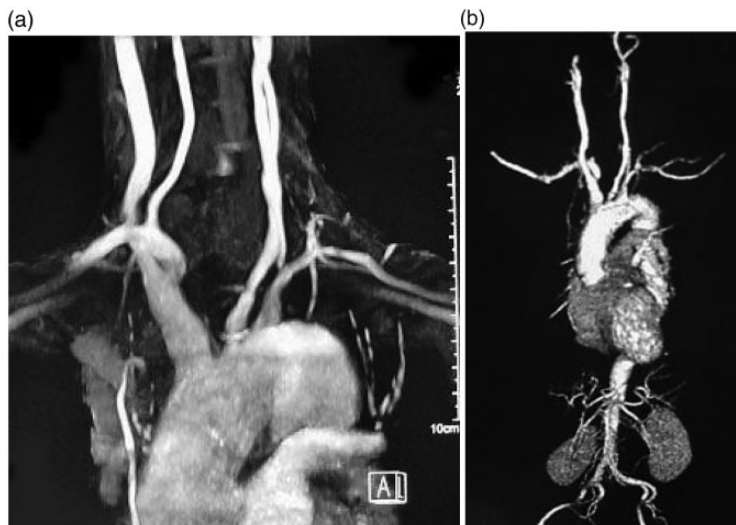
Imaging findings. (a) Chest magnetic resonance angiogram. Stenosis of the left subclavian artery and left-side common carotid artery is observed. (b) Contrast-enhanced three-dimensional computed tomography angiogram extending from the chest to the pelvis. Stenosis of the left subclavian artery and left-side common carotid artery is observed; however, there are no abnormalities in the main peripheral vessels branching from the descending aorta.
